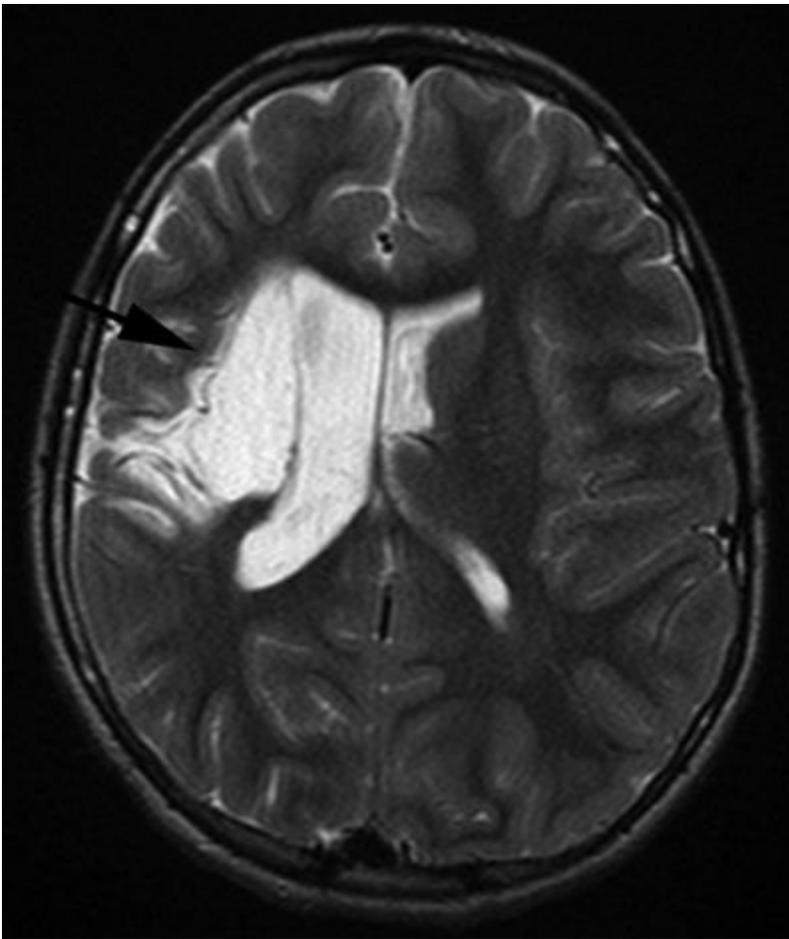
Remote infarction. Axial T2-weighted image from MRI without gadolinium in a 9-year-old boy with a history of posttraumatic occlusion of the right internal carotid artery as the infant shows cystic encephalomalacia in the right MCA territory (arrow).
